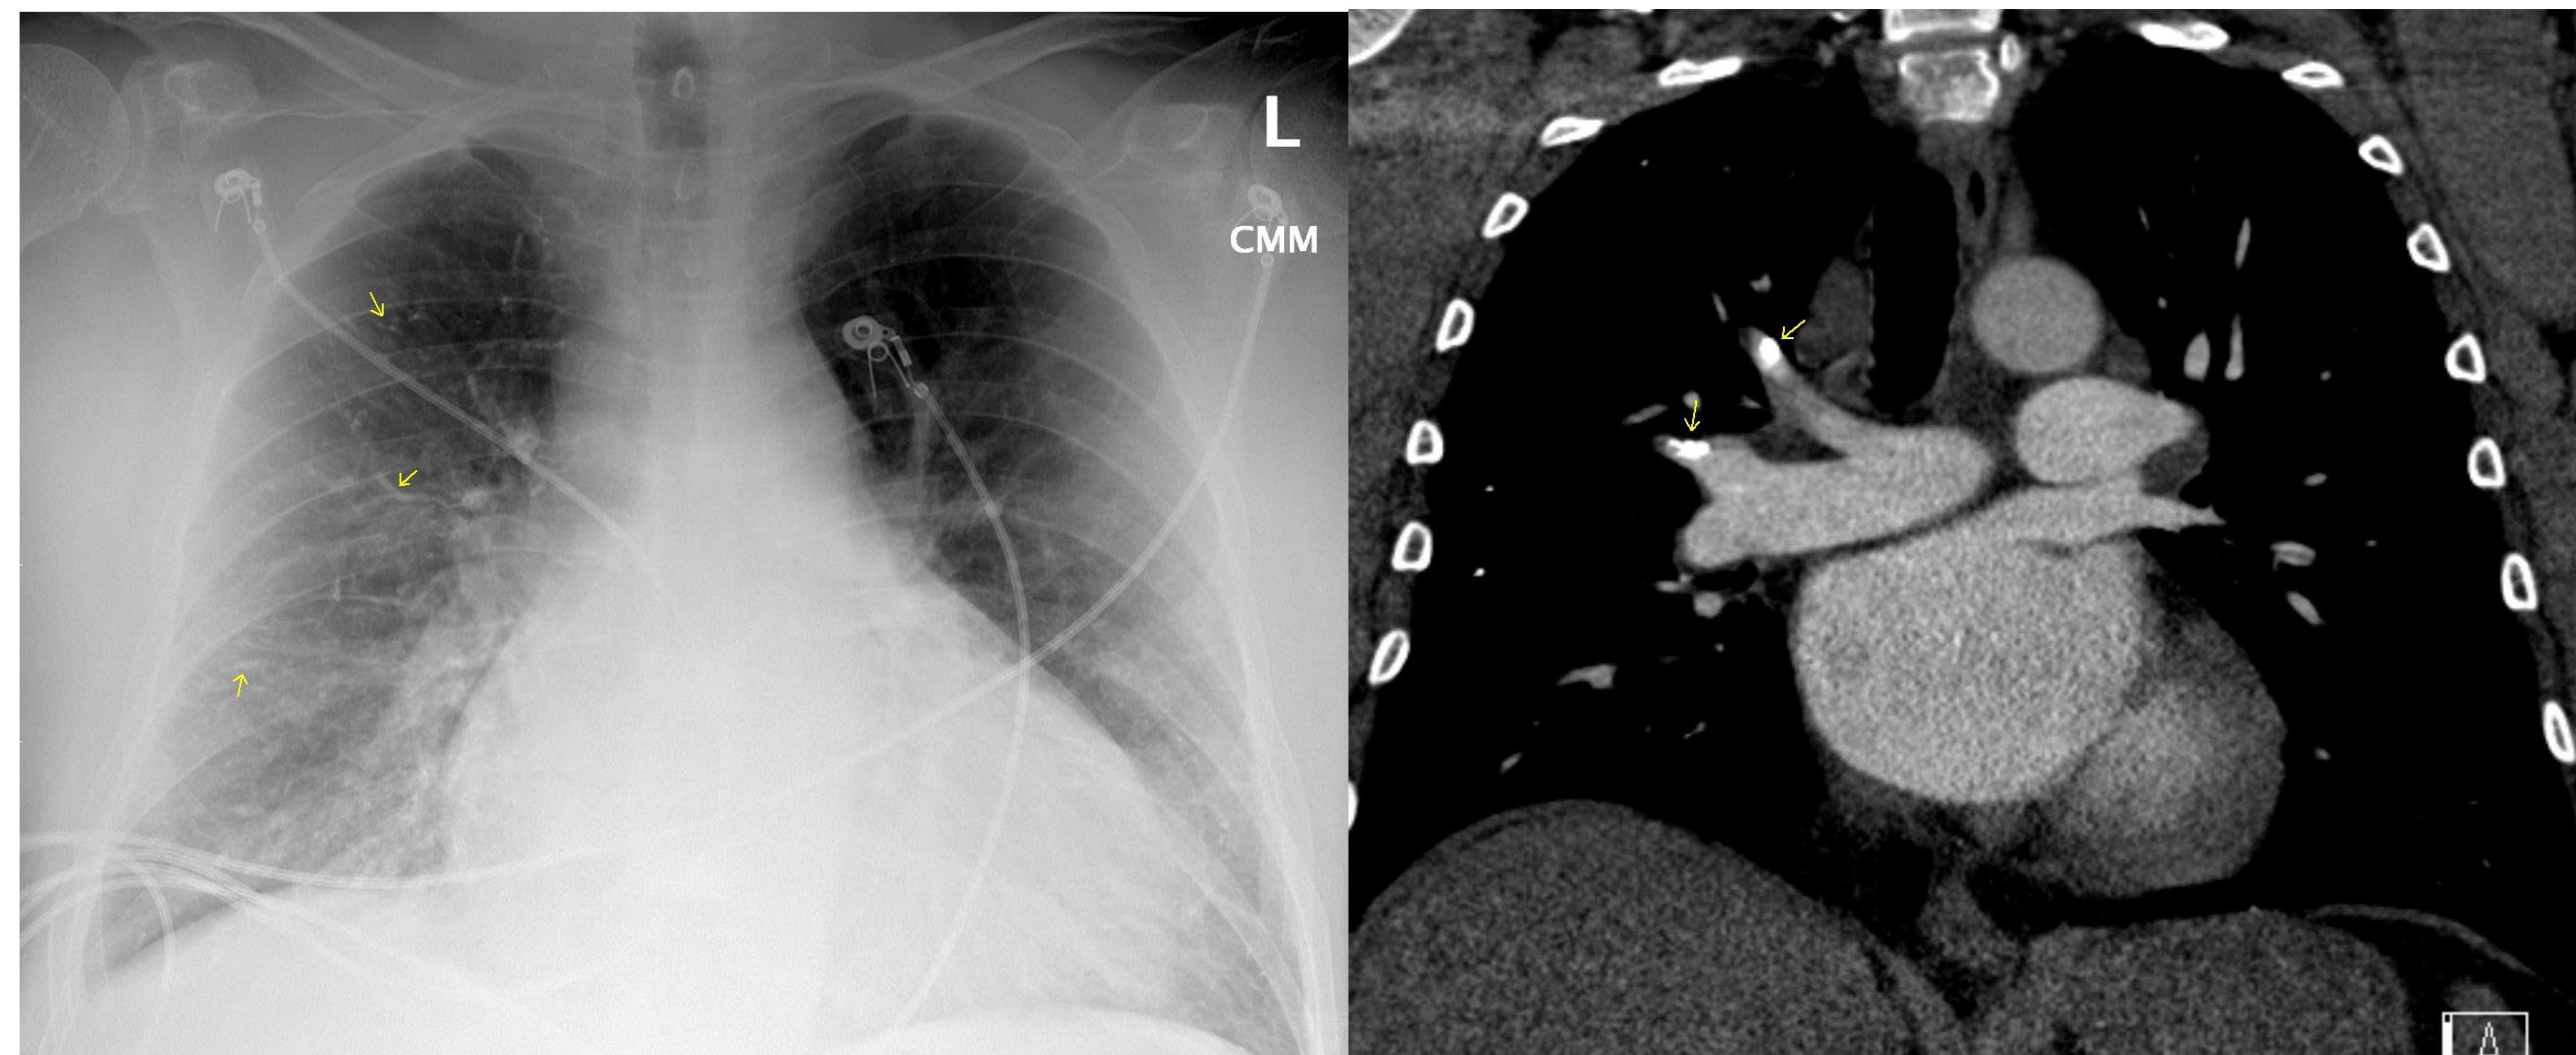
Initial chest X-ray demonstrated punctate pulmonary parenchymal densities.
